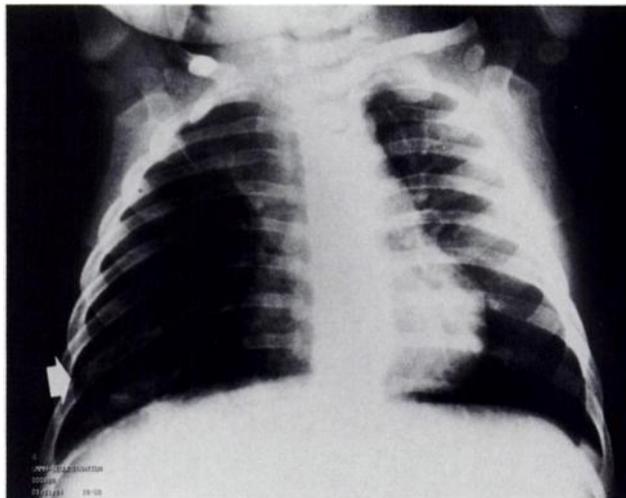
PA chest x-ray of Patient 1 showing partially cystic density in right lower lung field (arrow).
